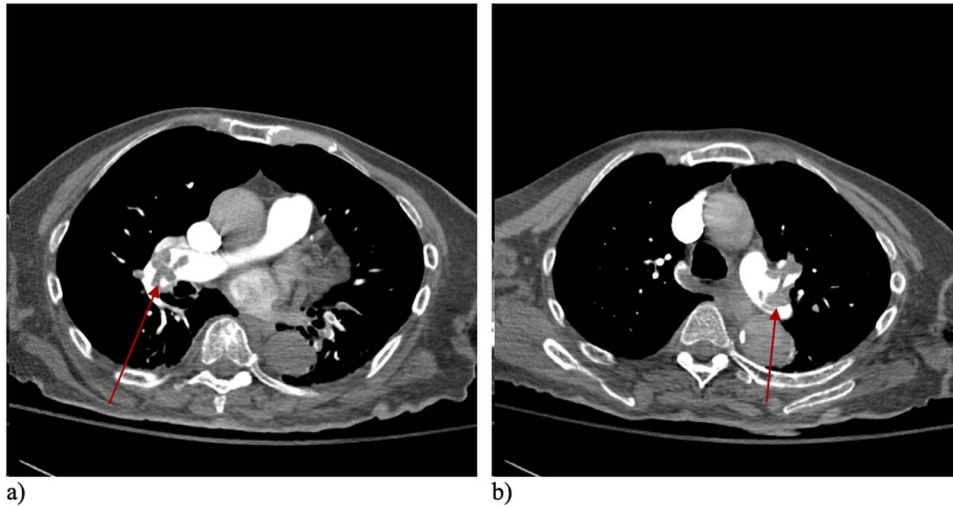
Axial CT angiography showing saddle pulmonary emboli with evidence of filling defects in the right (a) and left (b) main pulmonary arteries.
